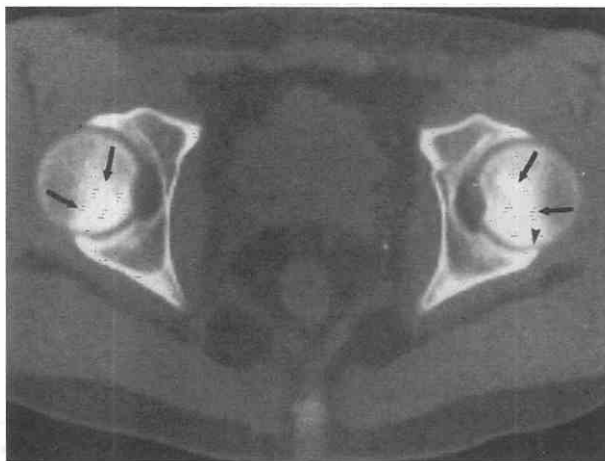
Bilateral avascular necrosis (AVN) of the femoral heads in a 22-year-old man receiving steroid therapy for Crohn disease. CT scan shows focal sclerosis in both femoral heads posteriorly (arrows), typical of AVN with minimal cortical collapse (arrowhead) on the left.
